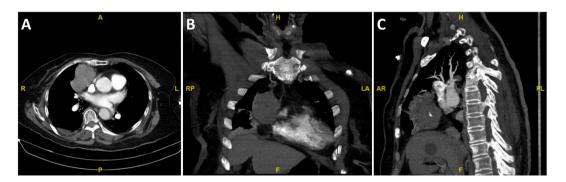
(A) Transverse, (B) coronal, and (C) sagittal sections of the chest computed tomography angiogram demonstrating a 7×4.7 cm lobular homogenous hyperdense tumor with modest enhancement and oval calcification at right anterior mediastinum.
